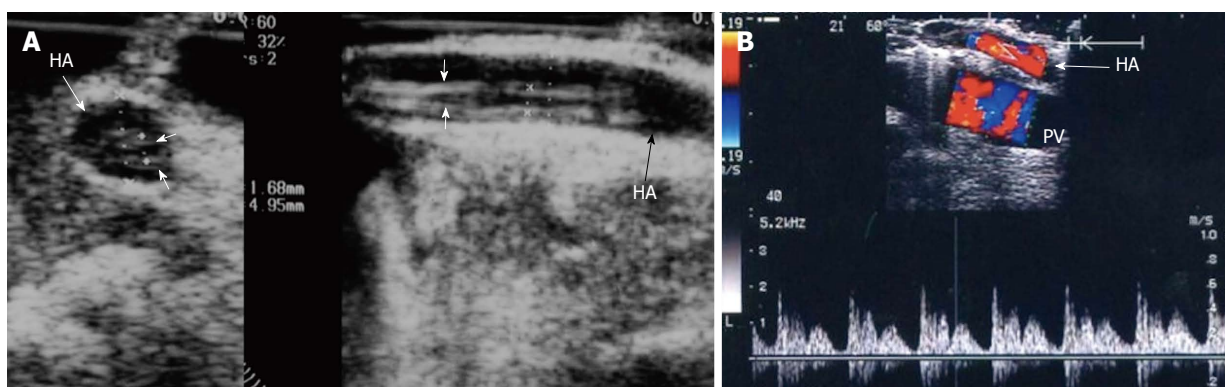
Intra-operative dissection of the recipient hepatic artery. A:IOUS B-mode image in axial and longitudinal scans, showing circumferential dissection of the recipient HA with 2 parallel echogenic intimal flaps seen within; B: Color Doppler image, showing a characteristic double-hump early presystolic pulse waveform, signifying ongoing dissection, that necessitates revision of the anastomosis. HA: Hepatic artery.
